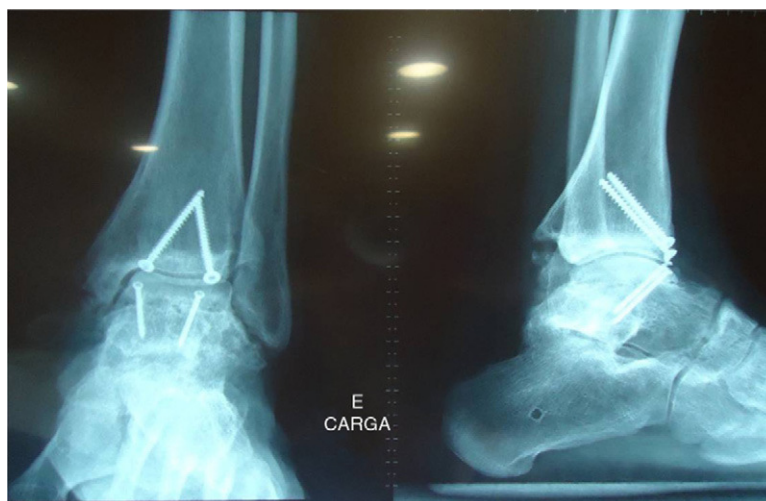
Weight-bearing X-ray of the left ankle 15 months after surgery.
